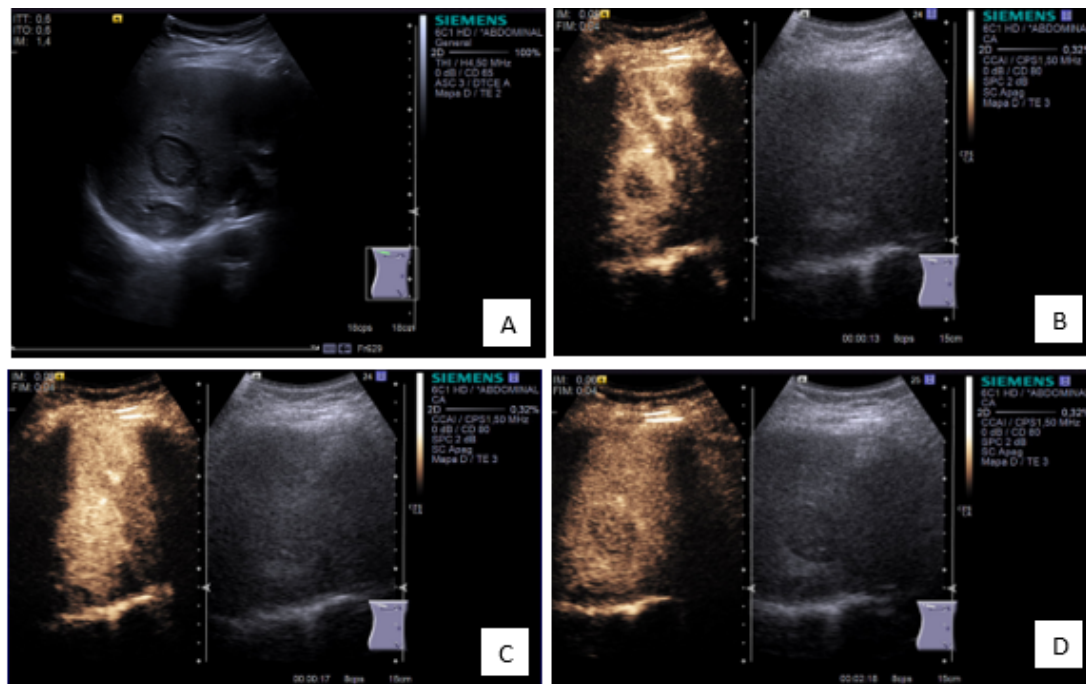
A. B-mode ultrasound: Isoechogenic liver lesion surrounded by a hypoechoic halo. B-D. CEUS. B,C: arterial phase. Rim hyperenhancement of liver lesion. D: late phase. Washout in liver lesion.
